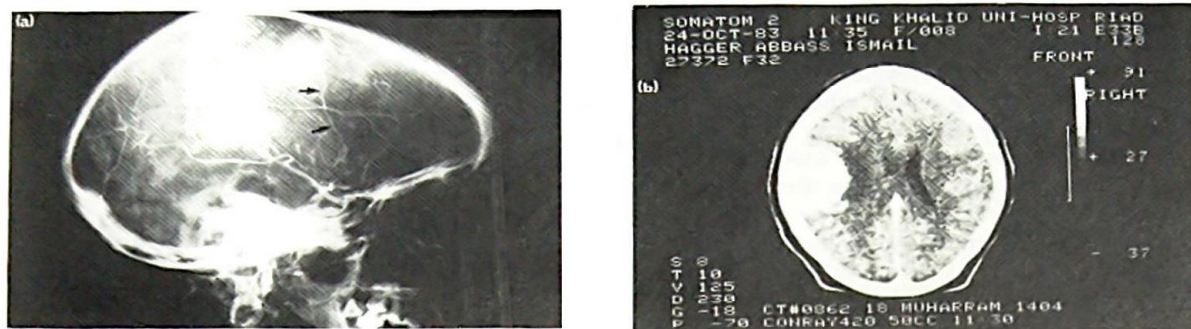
(a) Lateral view of carotid angiogram showing anterior parietal blush fed by arteries, one (external carotid branch) of which shows paradoxical enlargement (\uparrow). (b) CT of brain from (a). Homogenous area of high attenuation values contiguous to internal table in the left parietal region and with some compression of the left lateral ventricle.
